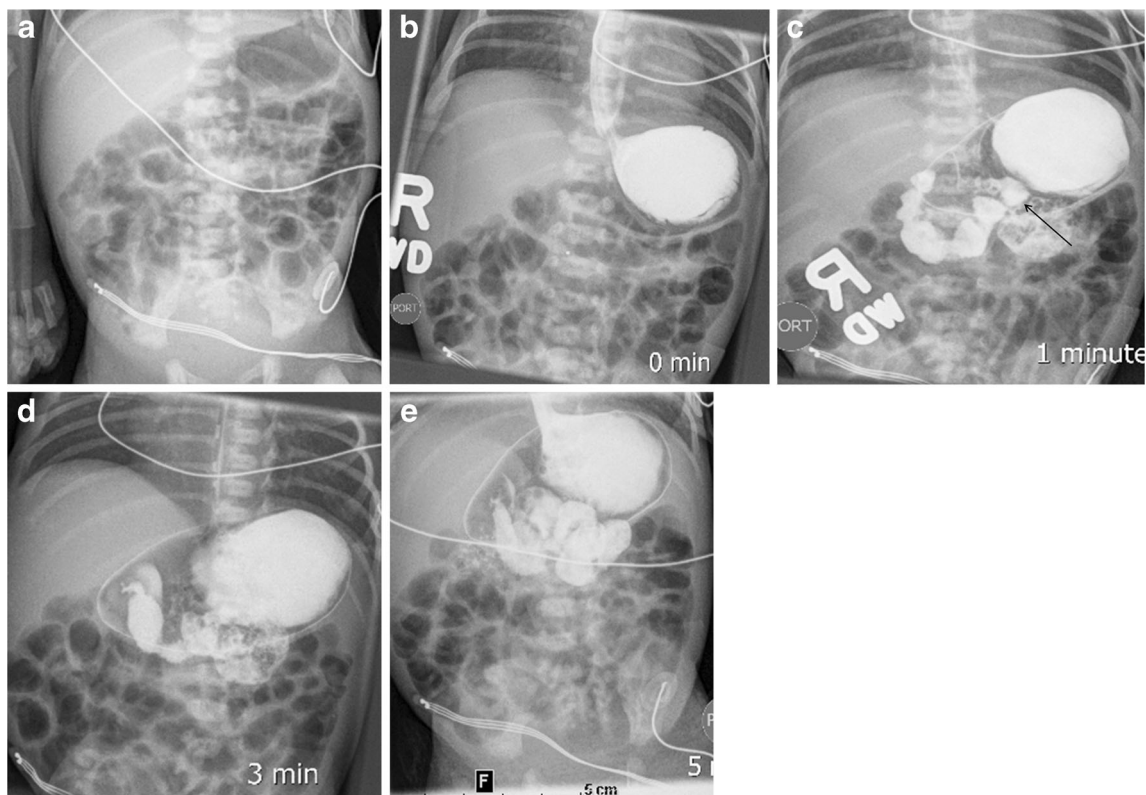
Images from a bedside UGI examination in a 5-day-old boy, 27 weeks' gestational age, include a scout radiograph (a), a radiograph obtained immediately after contrast medium administration via the enteric
